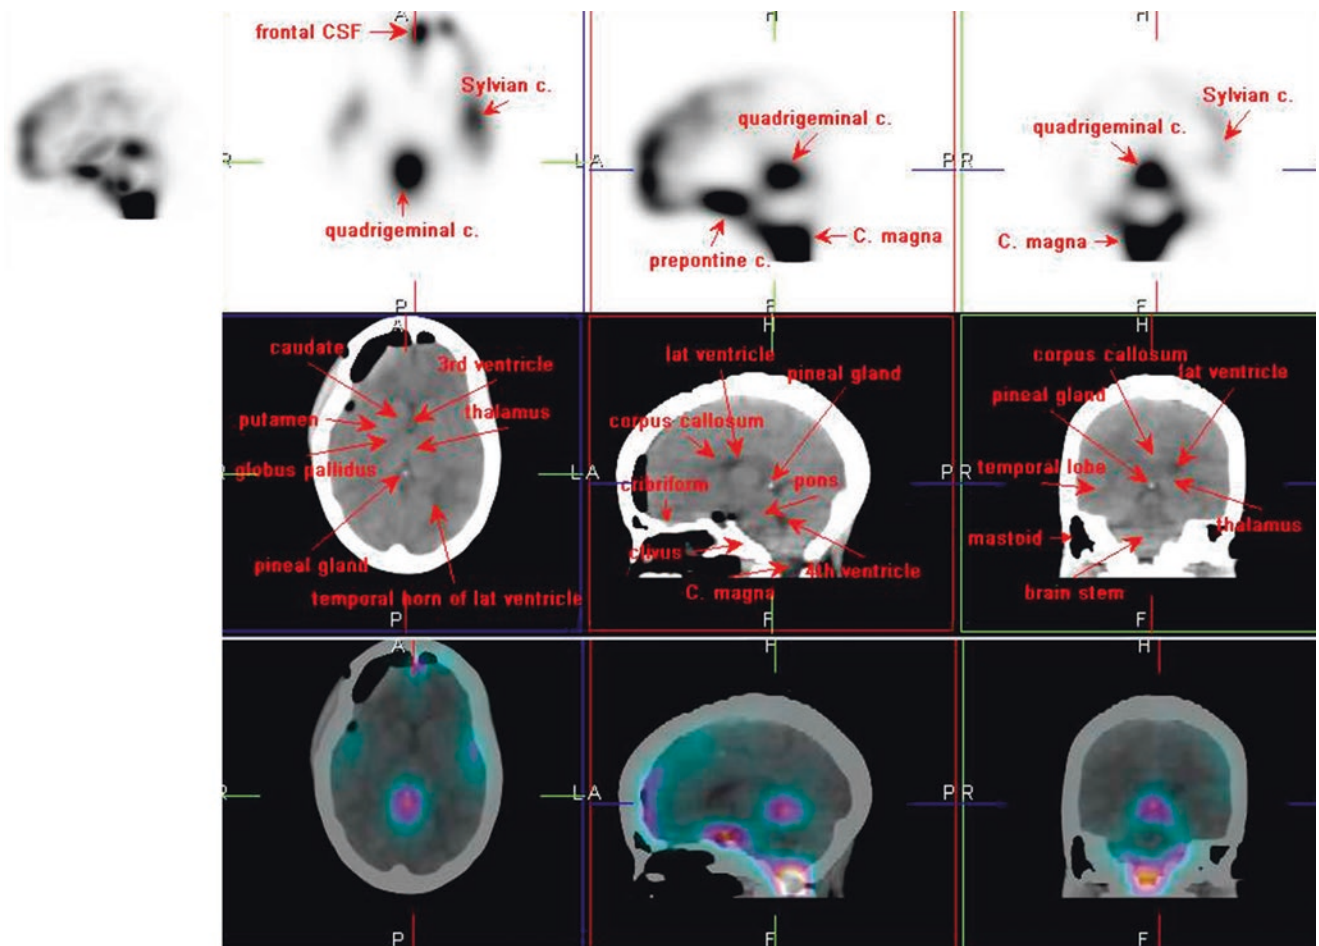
¹¹¹In-DTPA SPECT/CT
